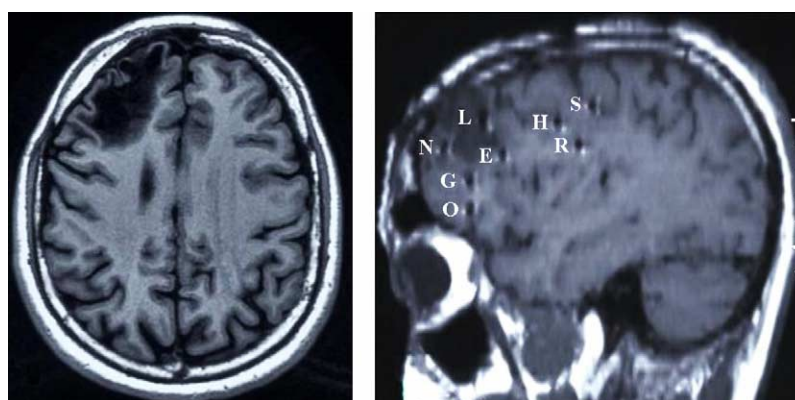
Left side:* Pre-operative MRI showing the right frontal post-abscess. *Right side:* Electrodes implanted in the right frontal region of patient 2. Note that electrode S was located in right SMA-proper.
